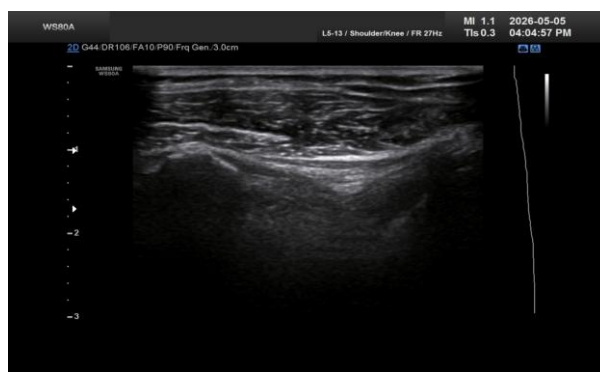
Demonstrates the normal appearance of the coracohumeral ligament on ultrasound imaging in an asymptomatic colleague.
